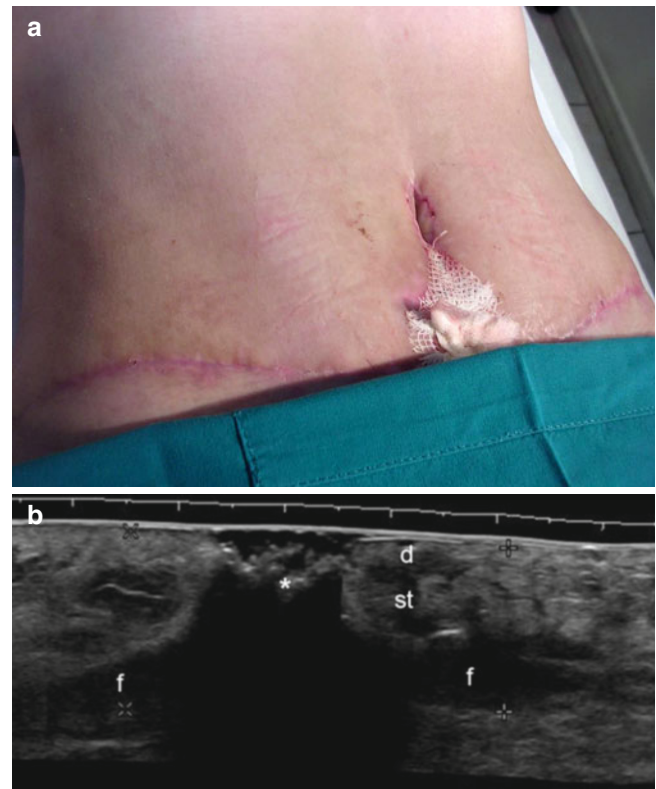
(a, b) Abdominoplasty. (a) Clinical image of a patient with a history of recent abdominoplasty. (b) Grey scale ultrasound image (transverse view) shows a anechoic fluid collection (*f*) located between the subcutaneous tissue and the rectus abdominis muscles. The hyperechoic structure (*) in the surface that generates posterior acoustic shadowing artifact corresponds to the visible gauze. *Abbreviations:* *d* dermis, *st* subcutaneous tissue
